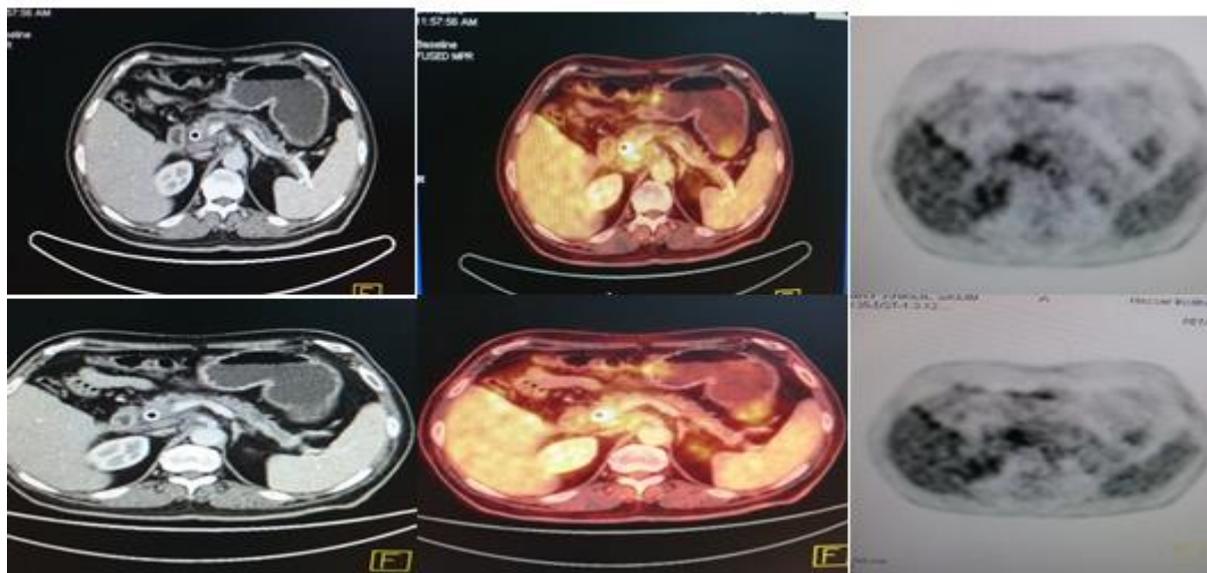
47 years old male patient presented by pancreatic head mass underwent ERCP, PET/CT revealed active head mass associated with nodal deposits.
